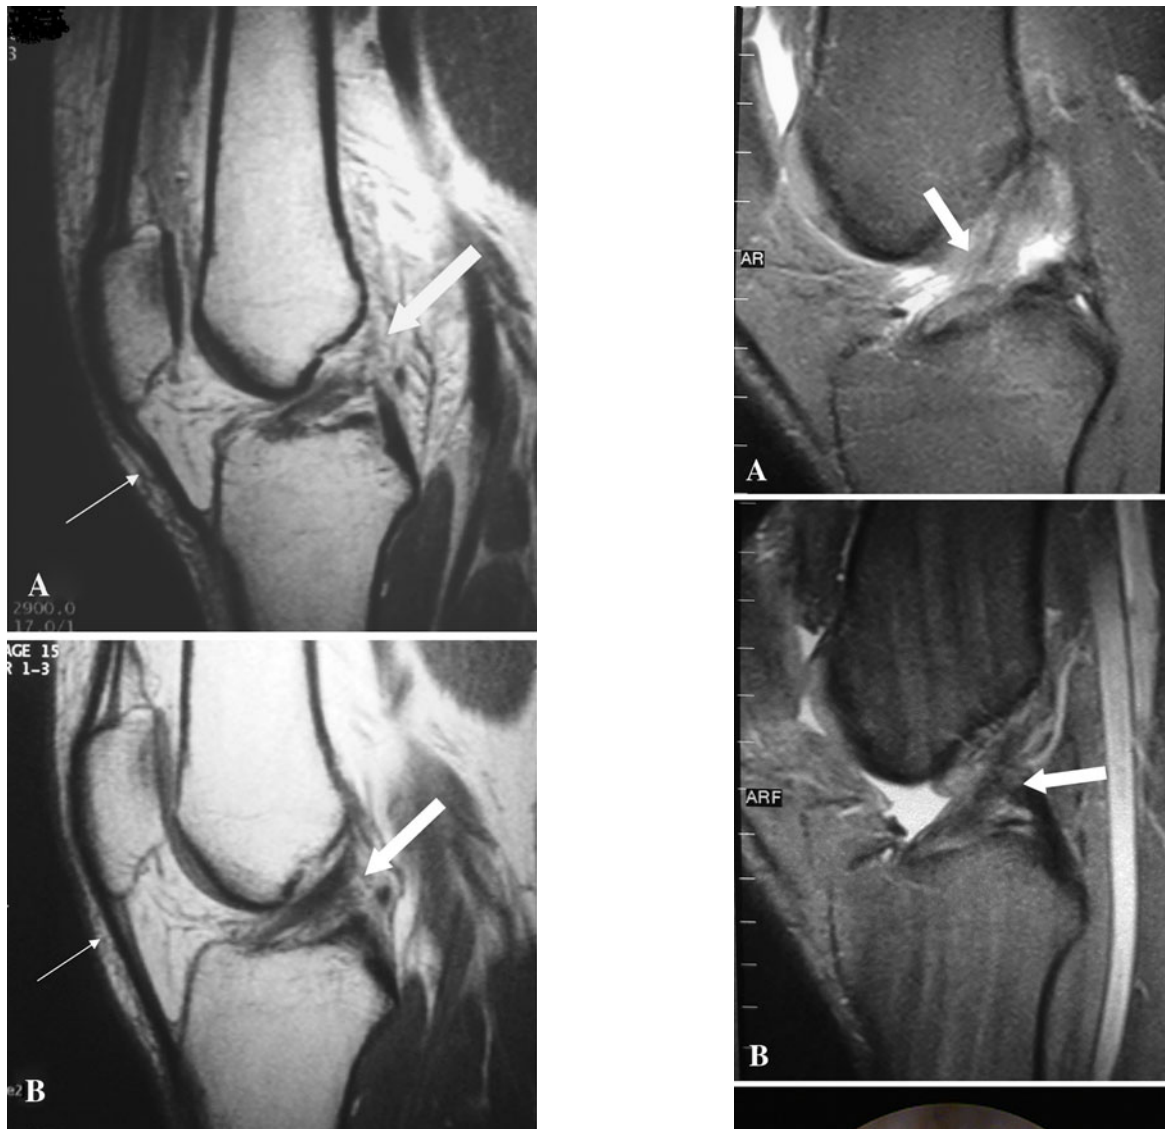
B (A) A MR image sagittal view of the knee demonstrates the complete proximal ACL rupture (thick arrow) and patella tendon buckling as a secondary sign of ACL rupture (thin arrow). (B) A MR image sagittal view of the same patient 3 years after the rupture shows ACL healing (thick arrow) and disappearance of the patella tendon buckling (thin arrow).
